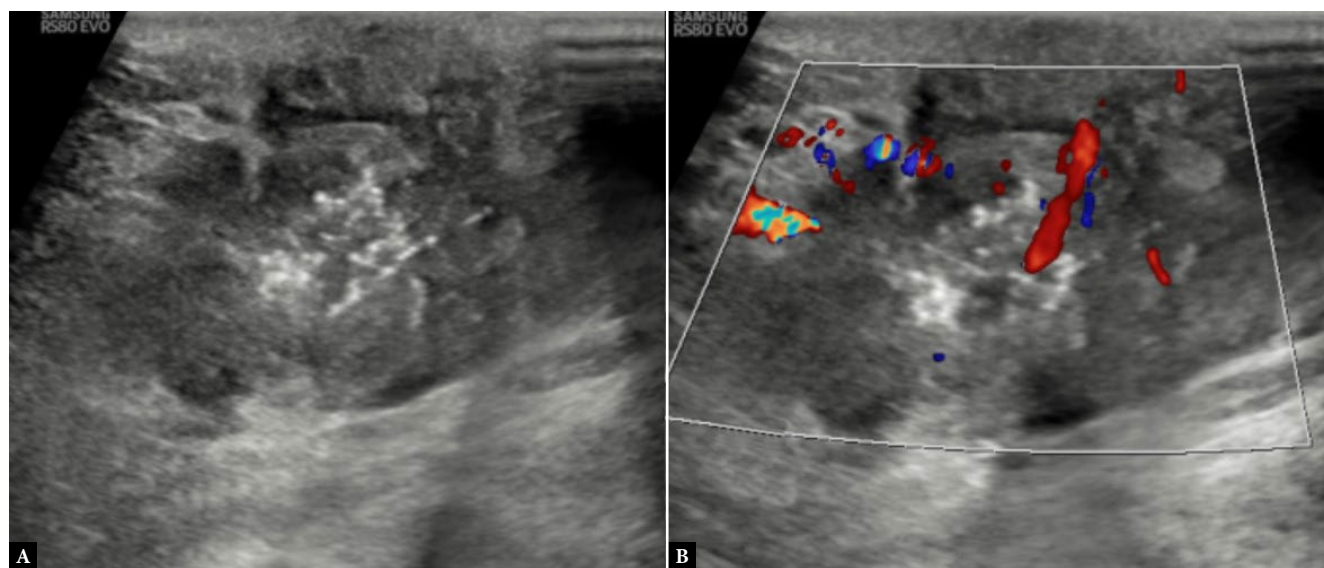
A 45-year-old female with invasive ductal carcinoma and HER2/neu-enriched type molecular subtype of breast cancer. Ultrasound image A. gray scale shows a heterogeneously hypoechoic mass with multiple echogenic foci of calcification B. color Doppler shows internal vascularity
